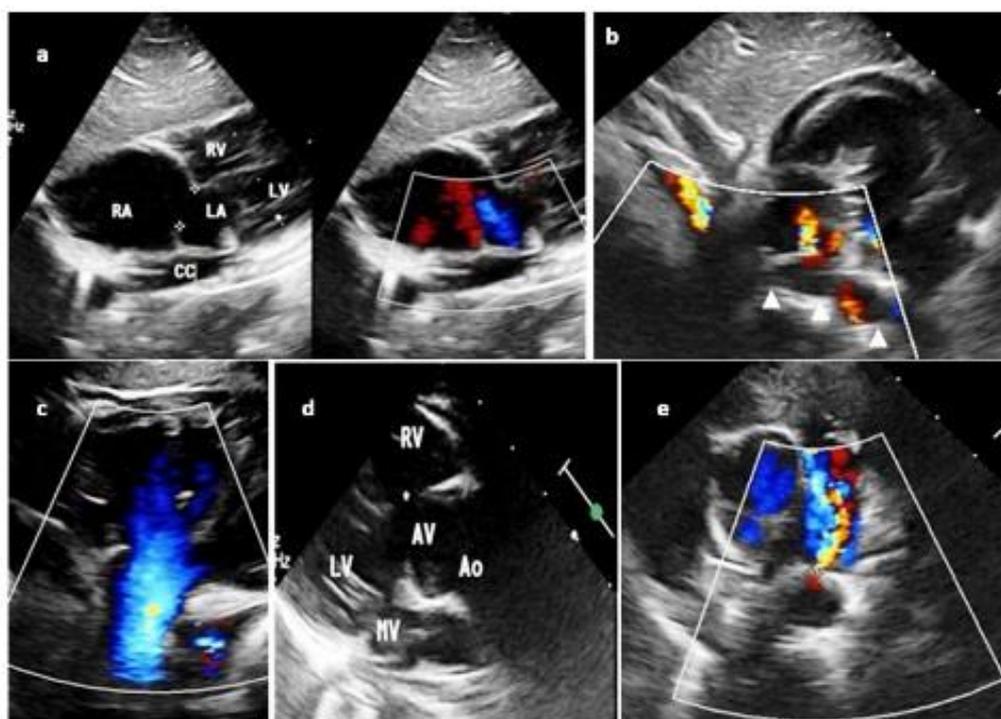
(a) Echocardiography in subcostal four chamber view demonstrated huge right atrium (RA), small left atrium (LA) with 8 mm ostium secundum atrial septal defect shunting right to left. Behind the left atrium is common chamber (CC). (b) Common chamber is (white arrow heads) draining into RA. (c & d) Five chamber and long axis views showing large ventricular septal defect shunting right to left with aortic (Ao) override. (e) Tiny patent ductus arteriosus (PDA) with shunt direction from aorta to pulmonary artery
